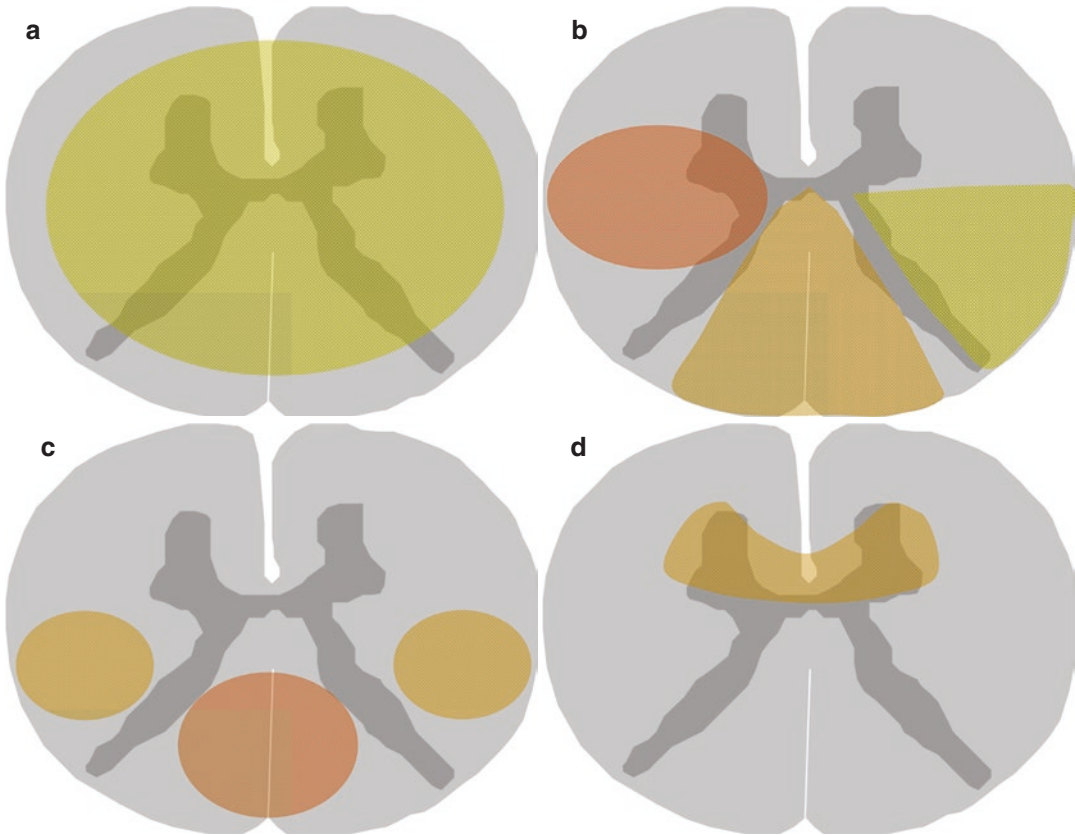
Differential diagnosis of myelopathies based on the patterns of spinal cord involvement on axial MR images. (a) Acute transverse myelitis. Centrally located lesion involving both halves of the cord. (b) Multiple sclerosis. Triangular or round in shape and mostly located
